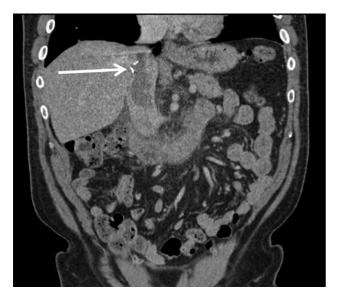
Case 3. Coronal CT image depicting extensive IVC thrombus surrounding the struts of a previously placed IVC filter (arrow).
